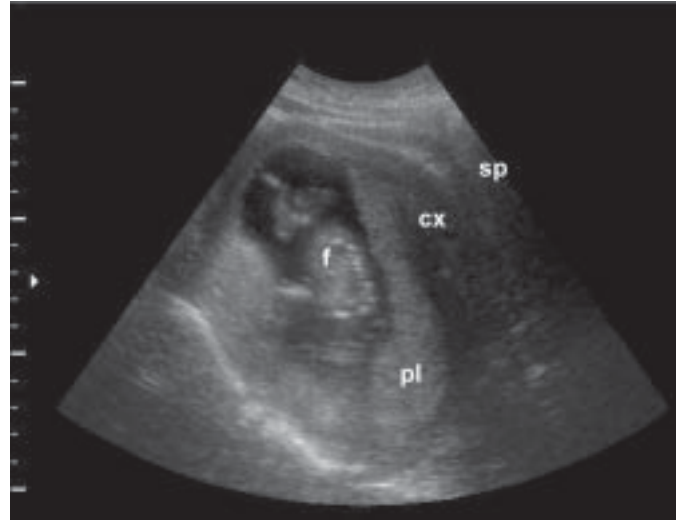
Transabdominal ultrasonography reveals a retroverted gravid uterus confined by the sacrum below and promontory above. (sp = pubic symphysis, cx = cervix, f = fetus, pl = placenta)
